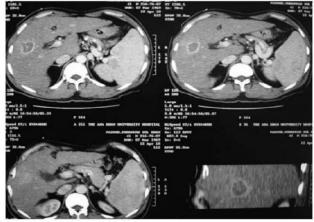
Immediate Post RFA CT segment IV lesion showing typical ring enhancement (inflammatory) and lesion is entirely avascular
